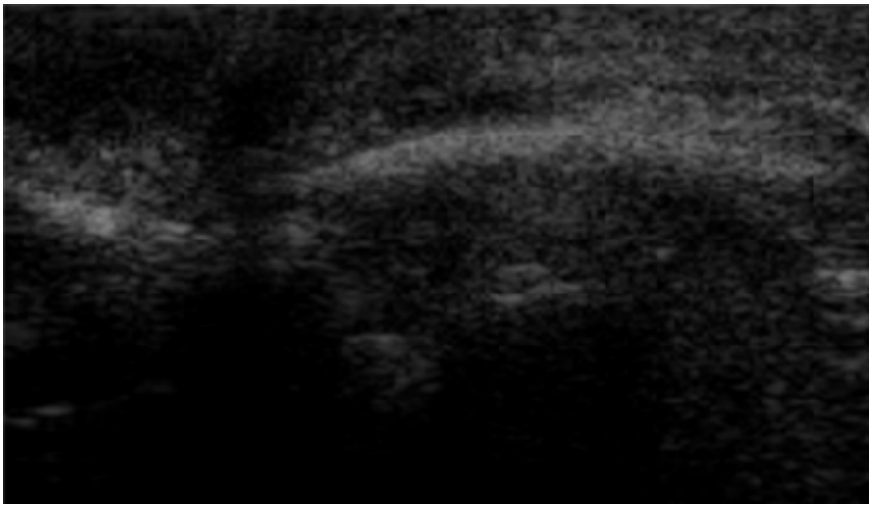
A 29-year-old man with nose swelling after nasal trauma. Longitudinal sonogram shows a depressed fracture line.
